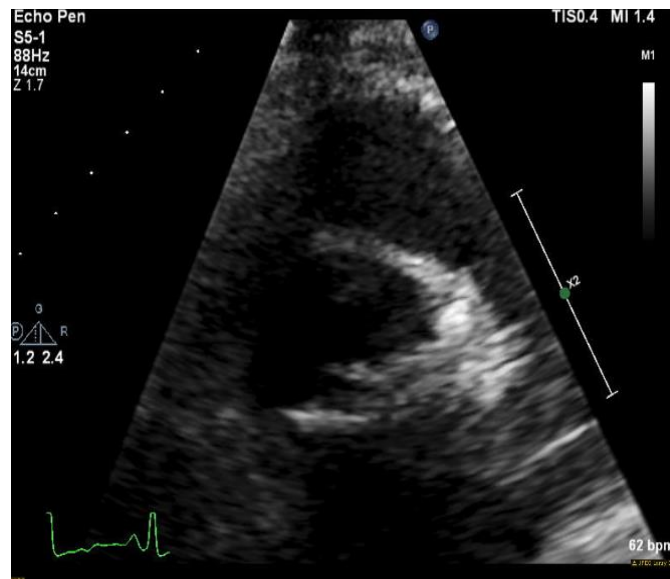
Technically difficult imaging of aortic valve in basal short axis view on transthoracic echocardiogram. Aortic valve leaflets appear mildly thickened but open well in mid systole.
